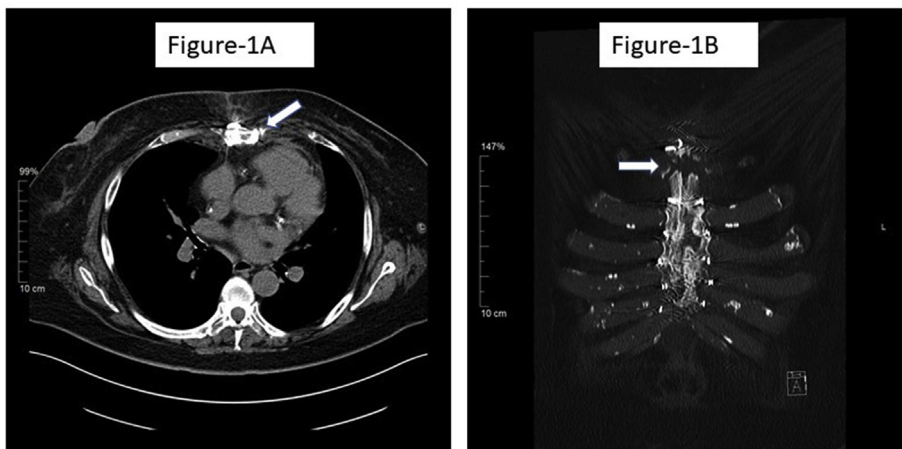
A and B (Day-198), Non-contrast CT of chest depicts a lucency in the body of sternum showing an osteolytic process.
